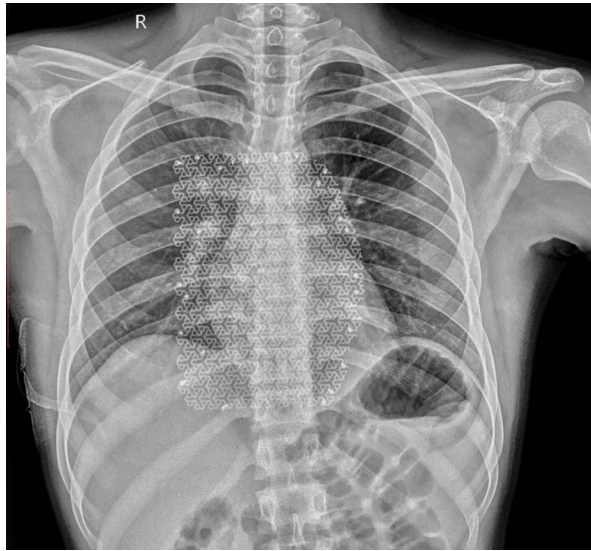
Chest X-ray (post sternal resection and reconstruction with mesh)
